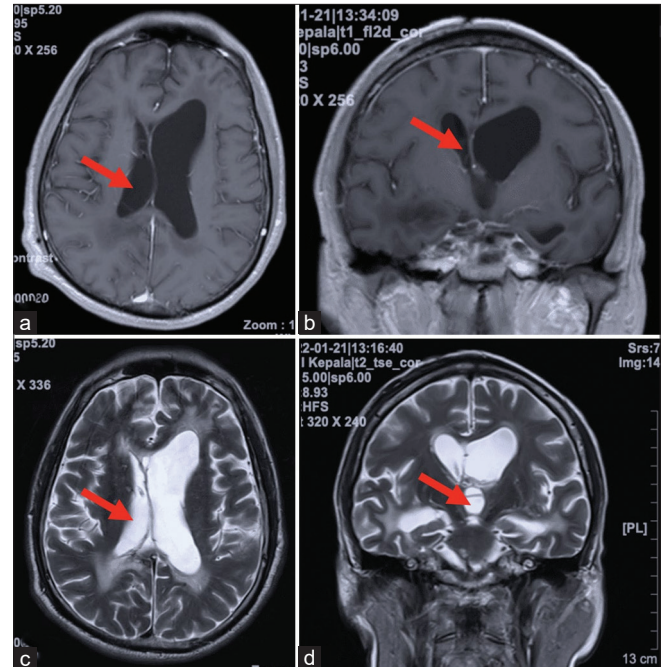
The magnetic resonance imaging depicts multiple loculated masses around the right lateral ventricle and third ventricle (red arrow). (a and b) Contrast-enhanced (a) axial and (b) coronal T1-weighted images. (c and d) (c) Axial and (d) coronal T2-weighted images revealing similar intensity between the mass and cerebrospinal fluid.
